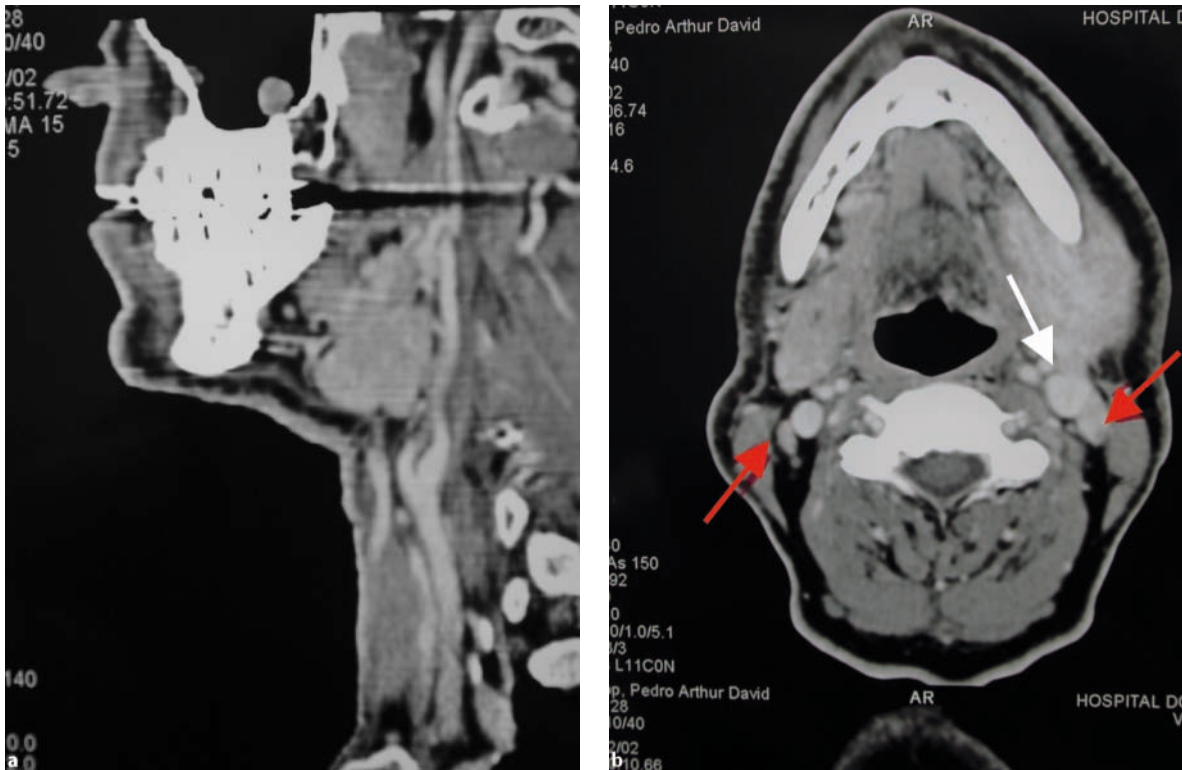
CT scan (sagittal view, a) revealing a heterogeneous tumor, with irregular borders, occupying the submandibular area. On axial view (b), the tumor reveals its aggressiveness involving the mandible, and invading the sublingual space and the jugular vein (white arrow). Bilateral lymph node metastases to levels II (high jugular chain) can also be seen (red arrows)
